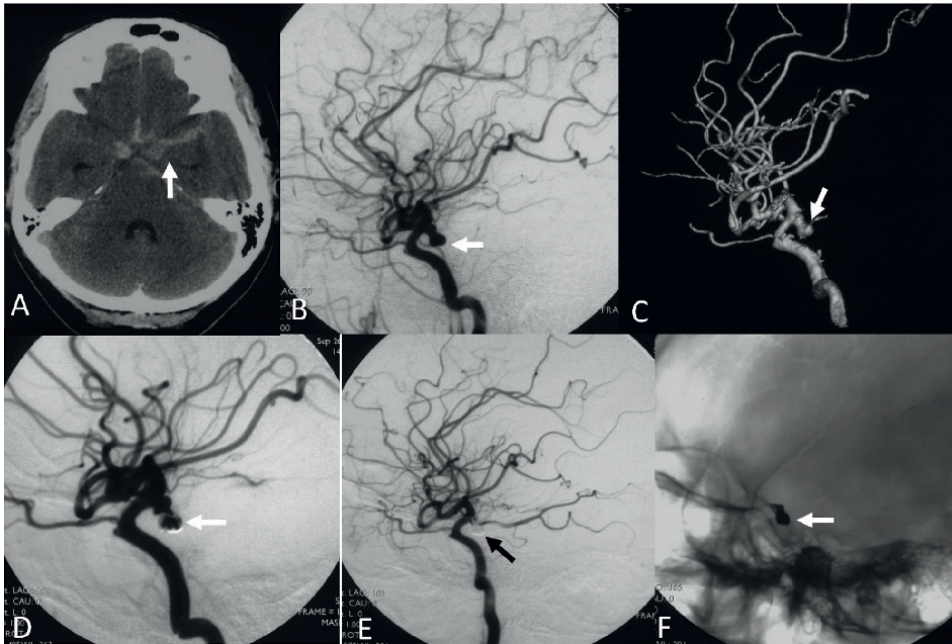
A 46-year-old woman with a ruptured posterior communicating artery aneurysm was coiled. A, cranial CT scanning showing the subarachnoid hemorrhage of the left supracellar cistern (arrow). B, lateral view of the left internal carotid artery injection. C, 3-D reconstruction of the left internal carotid artery injection. Showing the aneurysm of the left posterior communicating artery (arrows). D, lateral view of the left internal carotid artery injection showing the first 3-D coil was placed into the pseudo-aneurysm (arrow). E, lateral view of the left internal carotid artery injection after aneurysm coiling showing the disappearance of the aneurysm (arrow). F, unsubtracted image showing the coil mass (arrow).
